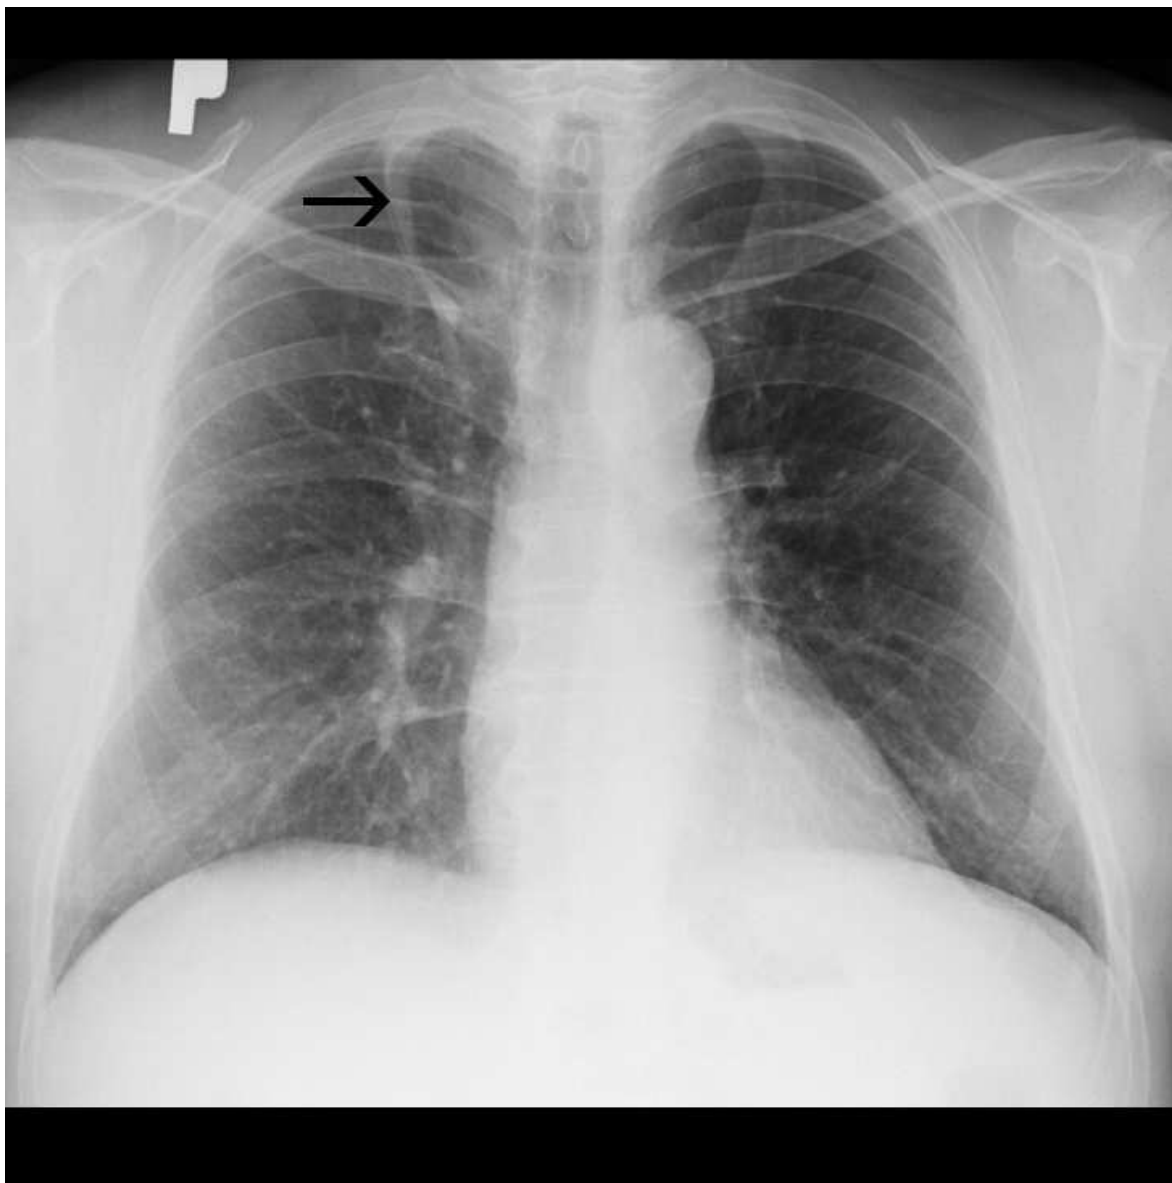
Anteroposterior chest radiograph. Azygos lobe in the upper right lung field as an incidental finding, black arrow indicates accessory fissure.
